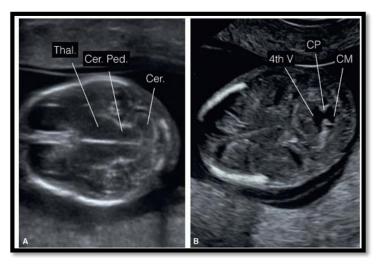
A 2 - D ultrasonography of the fetal head at 13 weeks of gestation obtained at the level of the posterior fossa A: At the level of the developing cerebellum (Cer.) and cerebral peduncles (Cer. Ped.). B: An oblique, slightly more inferior plane demonstrating the open fourth ventricle (4th V) connecting to the future cisterna magna (CM). (The Fetal Central Nervous System | Radiology Key, n.d.)
